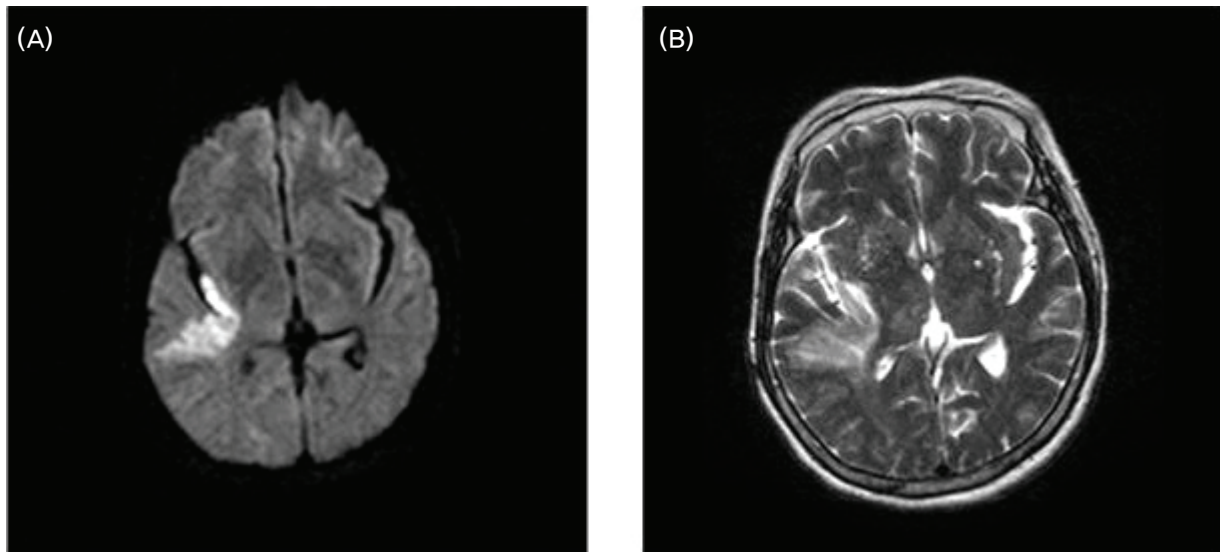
Diffusion-weighted magnetic resonance imaging (MRI) (A) and T₂-weighted MRI (B) of a 68-year-old woman, showing an ischemic stroke involving the right insular lobe.
